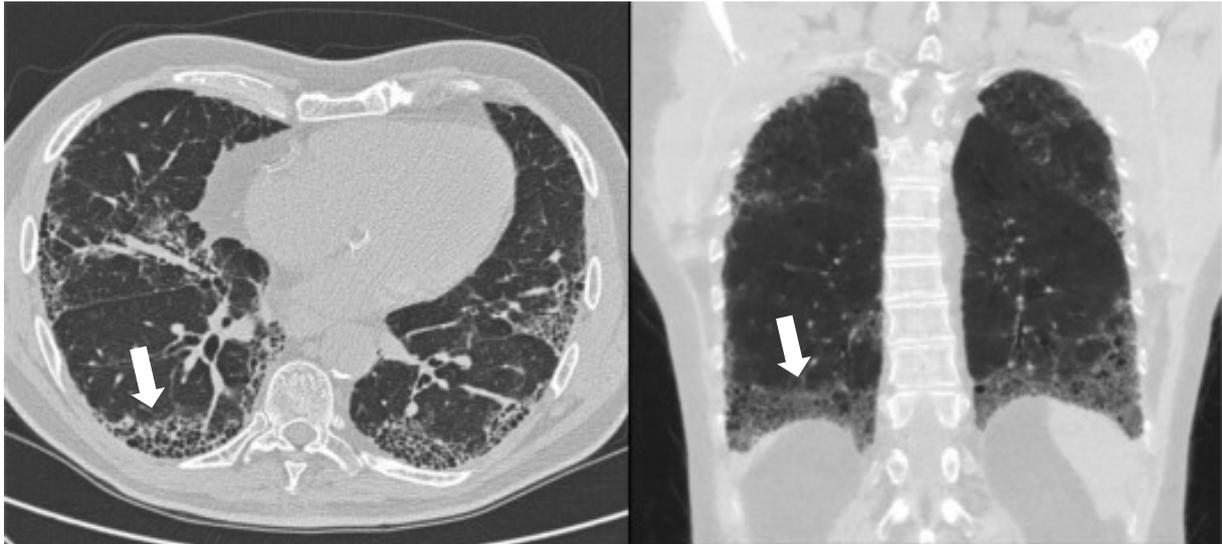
High resolution computed tomography (CT) of the chest showing classic UIP pattern in IPF. In both pictures, there are classic features including peripheral and basilar honeycombing and fibrotic changes (*arrows*) [16].
